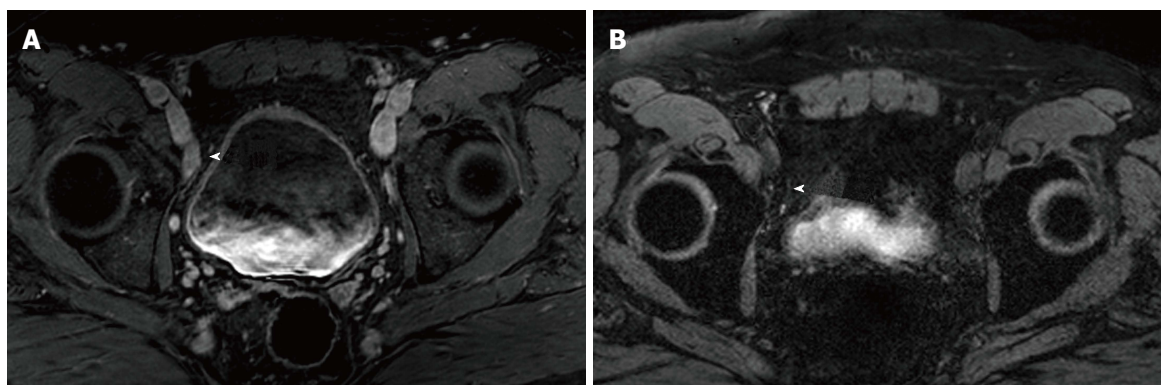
Selected images from a ferumoxytol enhanced magnetic resonance imaging in a 59-year-old man who underwent transrectal ultrasonography prostate biopsy for elevated PSA (10.8 ng/mL) which showed Gleason 3 + 4 disease of 4 cores. A: Initial prostate multiparametric T1 weighted post gadolinium magnetic resonance imaging (MRI) showed a 1.8 cm × 0.9 cm right external iliac chain lymph node that was suspicious based on size criteria (arrowhead); B: 24 h post injection of ferumoxytol (7.5 Fe/kg dose), T2* weighted MRI showed decreased signal intensity within the node (arrowhead), consistent with uptake of ferumoxytol. This was considered a benign lymph node based on these results. The patient underwent computed tomography guided biopsy for confirmation and the node was negative for malignancy.
